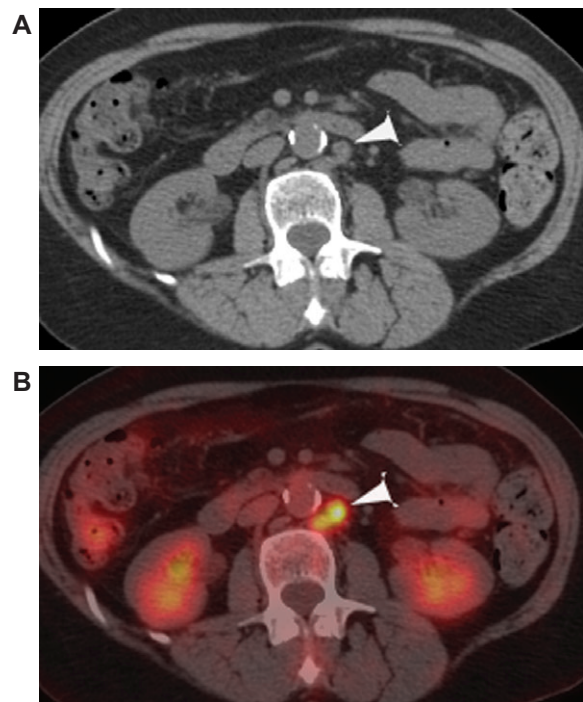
A 74-year-old female with endometrial cancer. (a) CT shows small retroperitoneal nodes that measure less than 1 cm; (b) axial PET/CT shows FDG uptake in these nodes, subsequently proven metastases.
